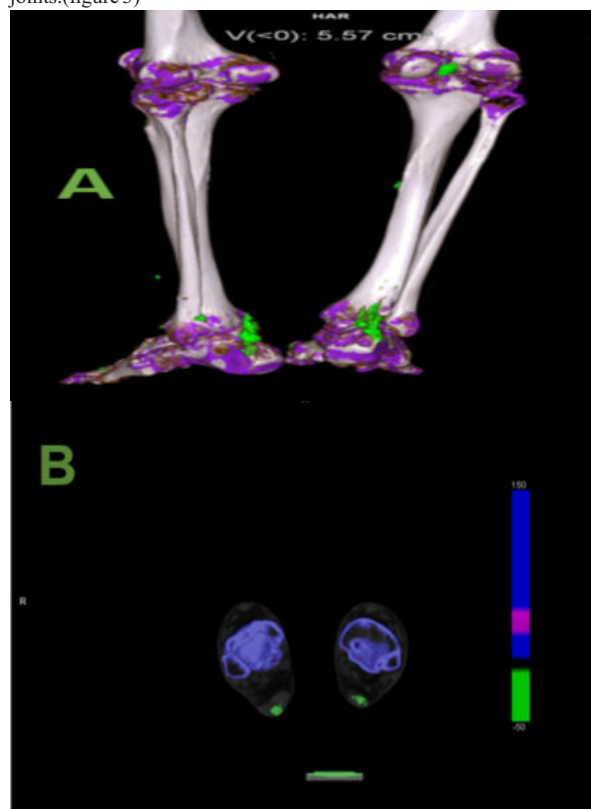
Dual energy CT (DECT) images of patient with suspected
